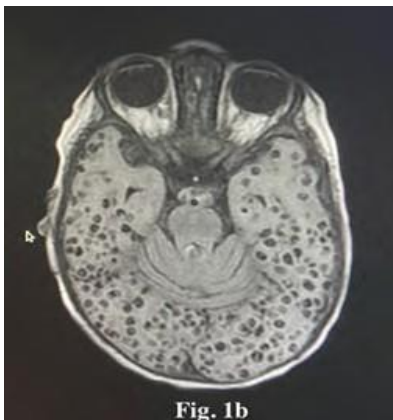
T1 weighted Axial view MRI showing innumerable inflammatory granulomas involving both of the brain parenchymas
